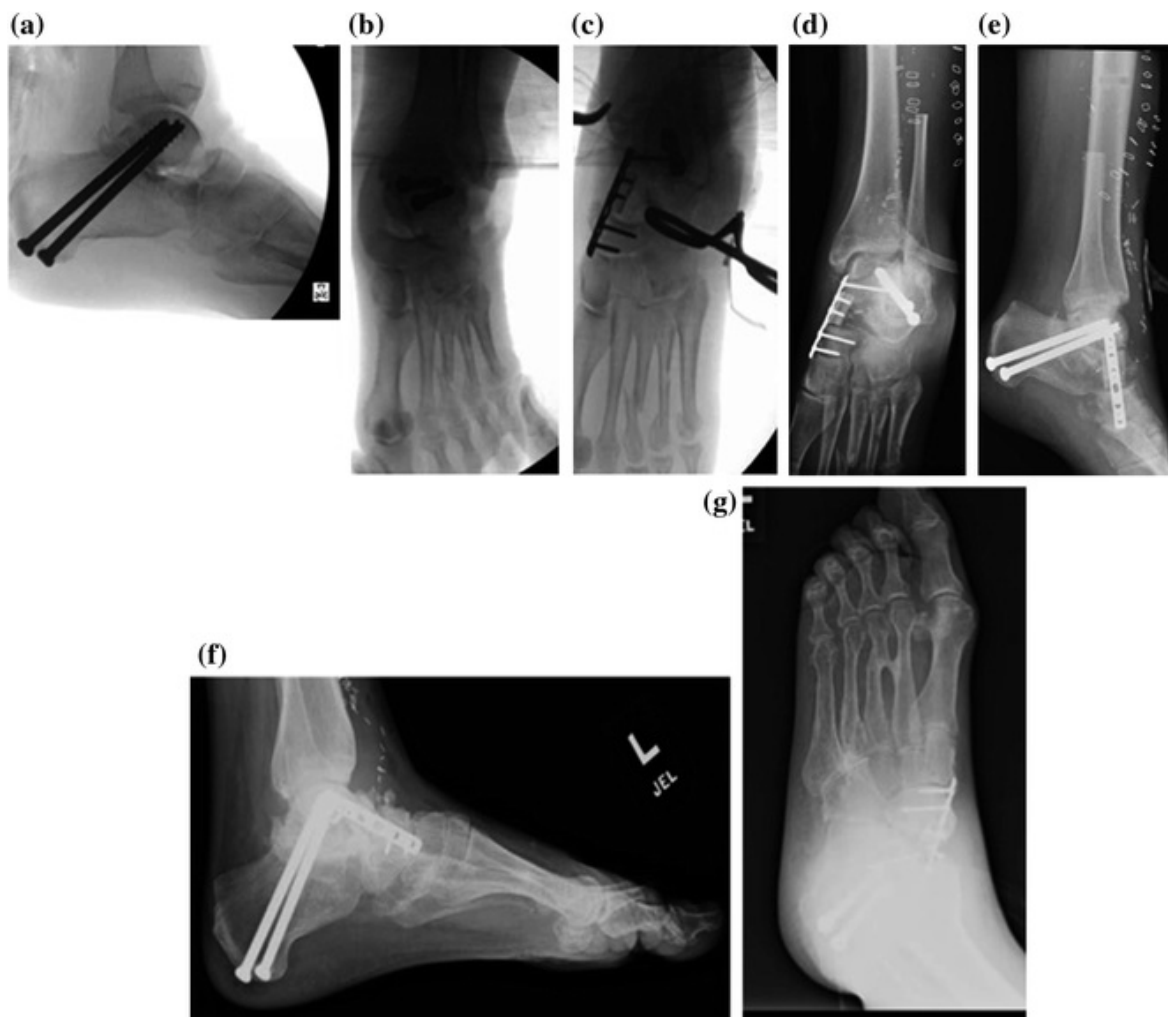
55-year-old female injured in a fall from a burning building, with a complex open fracture dislocation of the hindfoot. Complete traumatic loss of the talar head at the talonavicular joint. a–e Primary subtalar arthrodesis performed along with vascularized free fibula transfer to achieve both soft tissue coverage and a talonavicular arthrodesis. f–g Radiographs at 1.5 years demonstrate bony healing with a nonantalgic gait and complete return to function
